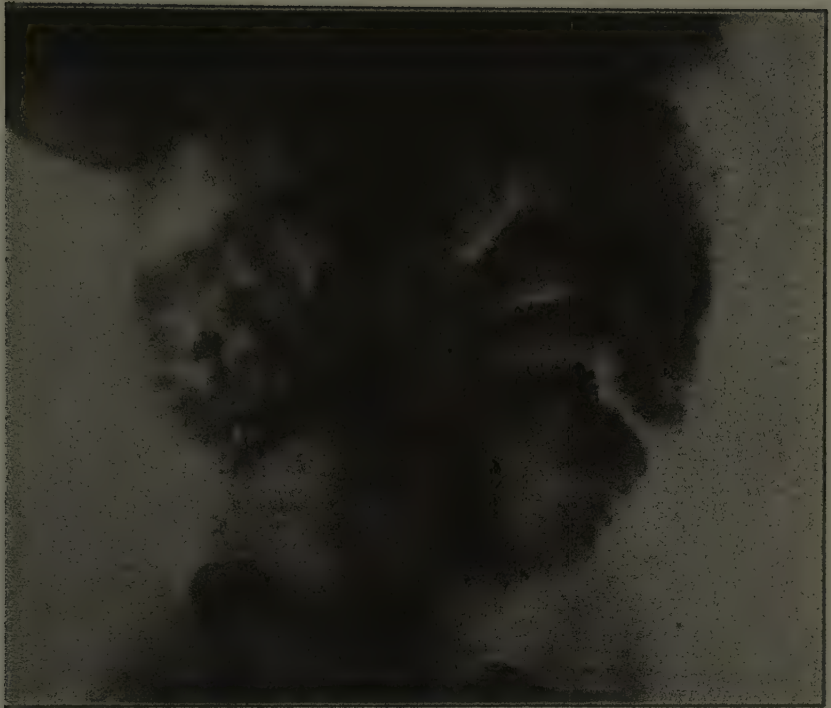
Plate of a case of gastro-enteric hypermotility, showing a spattering of barium throughout the small intestine so perfect that the coils can be made out in anatomy and position. (X-ray by author.)
